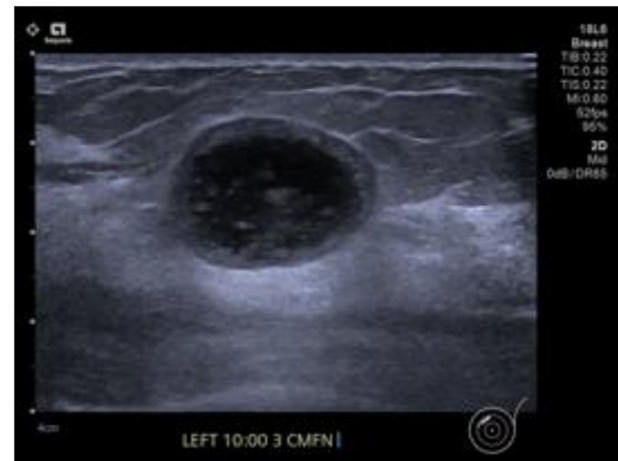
Ultrasound showed a circumscribed round anechoic mass with internal echogenic debris with thick wall at 10 o'clock 3cm from nipple. Posterior enhancement was appreciated.
